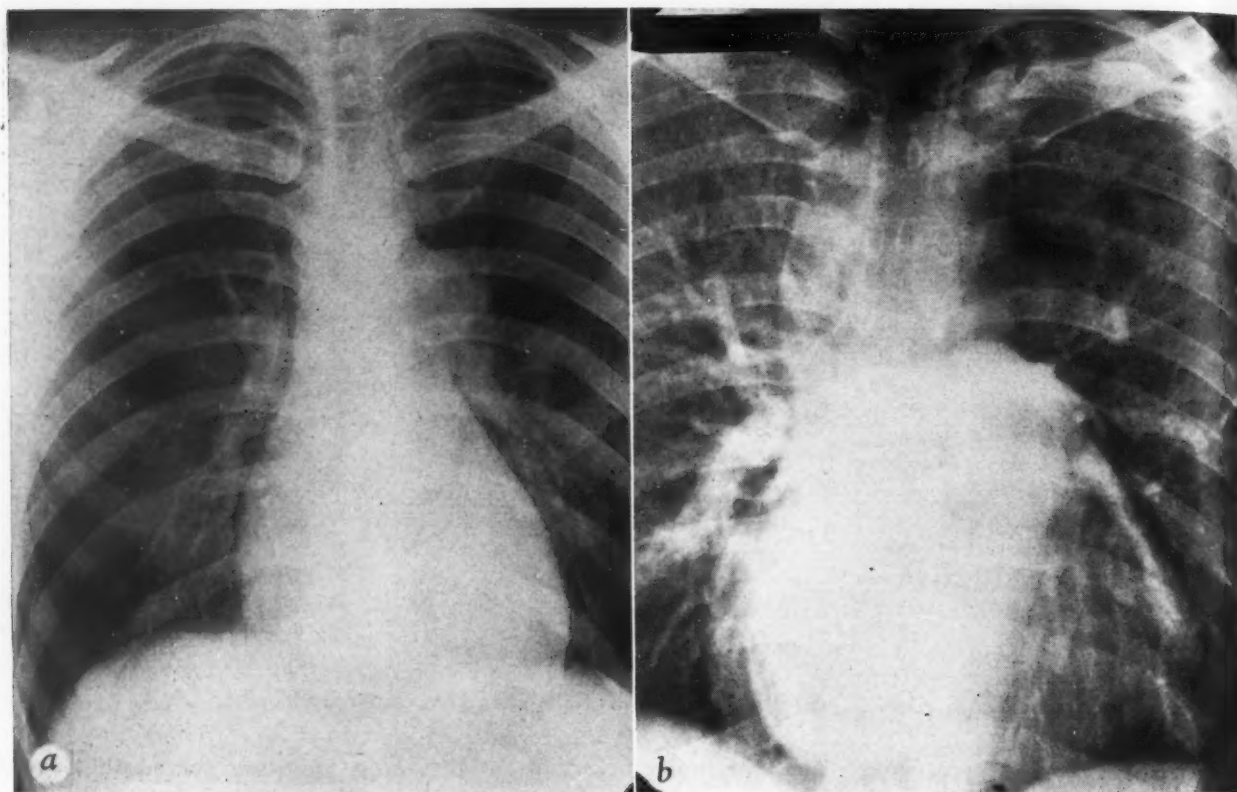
Case 4. (a) Roentgenogram of the chest. (b) Angiocardiogram.
